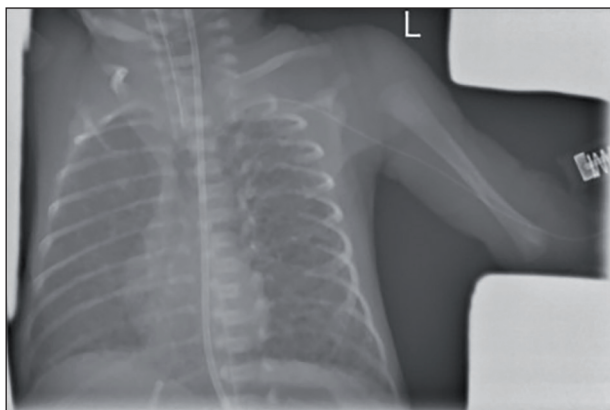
Chest X-ray: showing position of peripherally inserted central catheter (PICC) line.
